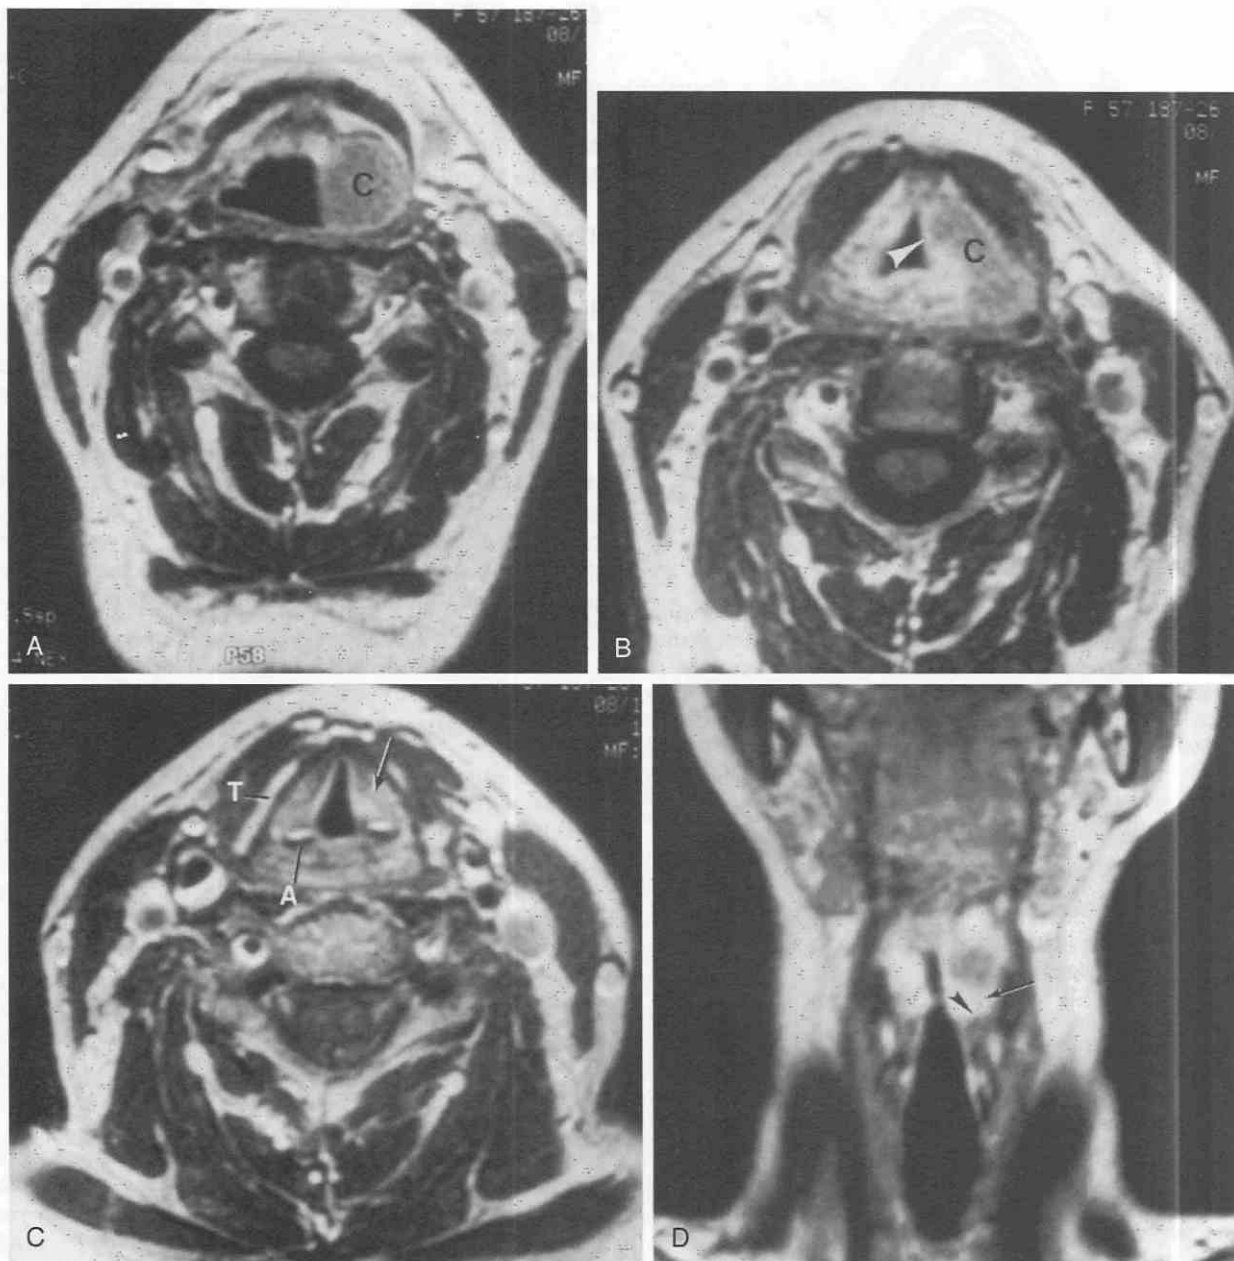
Saccular cyst (laryngocele). *A*, Postgadolinium T1-weighted axial image through the upper epiglottis shows the cyst (*C*). *B*, Slightly lower image shows the cyst (*C*) in the paraglottic space at the false cord level. The mucosa (*arrowhead*) is intact. *C*, Axial image through the true cord level shows no evidence of tumor. *A*, arytenoid; *T*, thyroid. The thyroarytenoid muscle (TAM) is shown by an *arrow*. *D*, Coronal image shows the lower margin of the lesion (*arrow*) above the upper edge of the TAM (*arrowhead*); thus, the cyst is above the ventricle.
